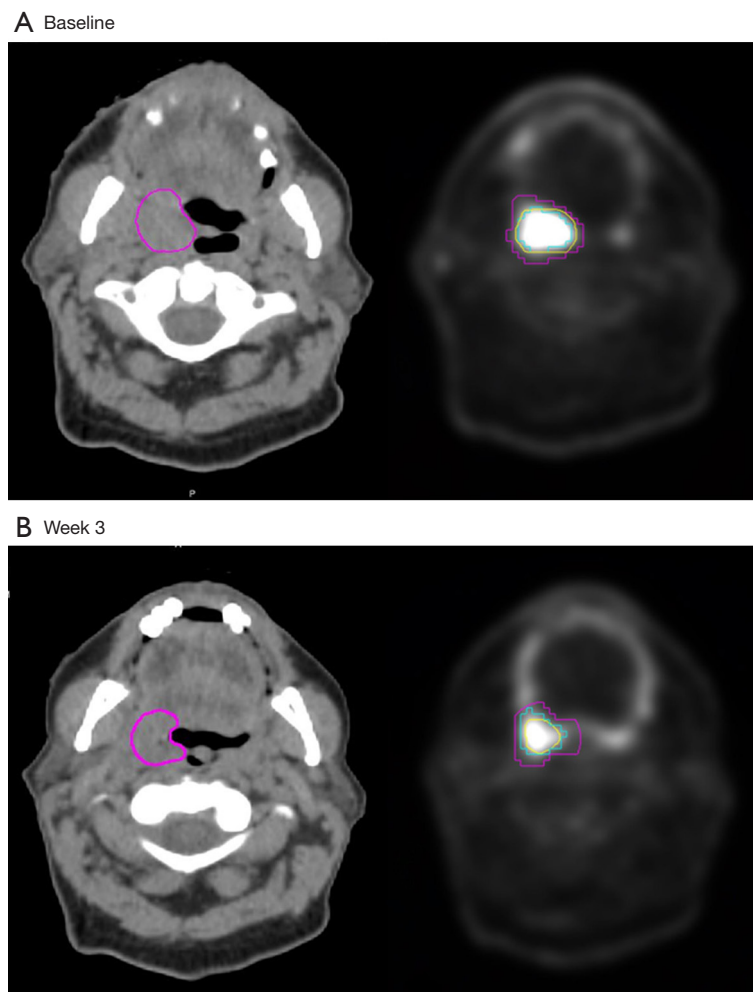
CT tumour (GTV) and FDG-PET MTV delineated using different region-of-interest segmentation methods; CT in red, PET Edge in yellow, MTV2.5 in pink, MTV40% in blue. (A) Baseline; (B) week 3. Resulting percentage change in tumour volumes for this patient at week 3 were -25.7% (CT), -76.2% (PET Edge), -41.9% (MTV2.5), and -25.0% (MTV40%). CT, computed tomography; FDG-PET, ^{18}F -fluoro-2-deoxy-D-glucose positron emission tomography; MTV, metabolic tumour volume; GTV, gross tumour volume.
